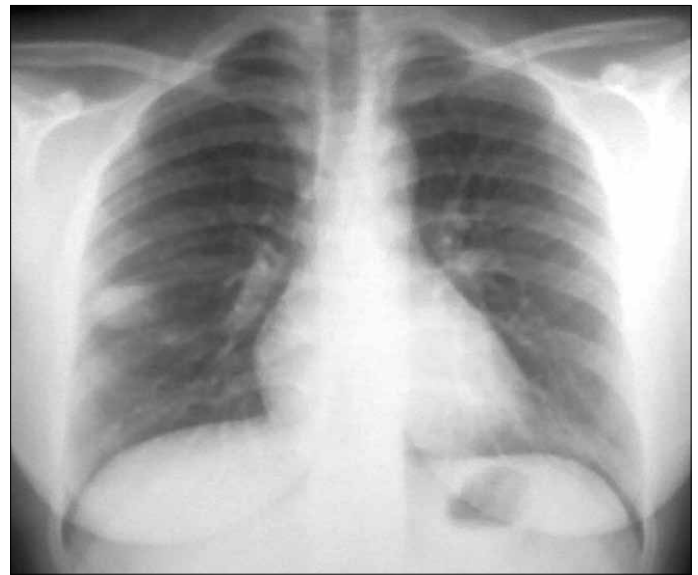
Control chest X-ray
